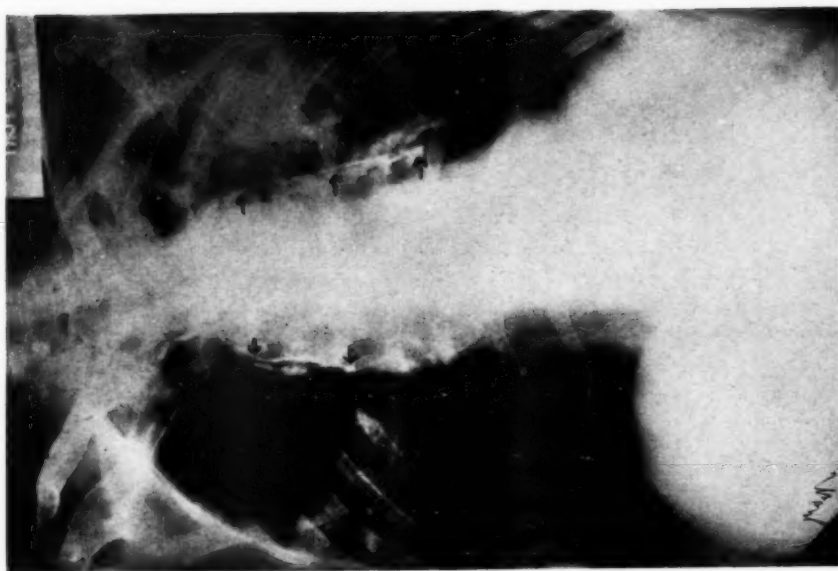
Ante-mortem x-ray film of aorta shown in Figs. 1 and 2.
